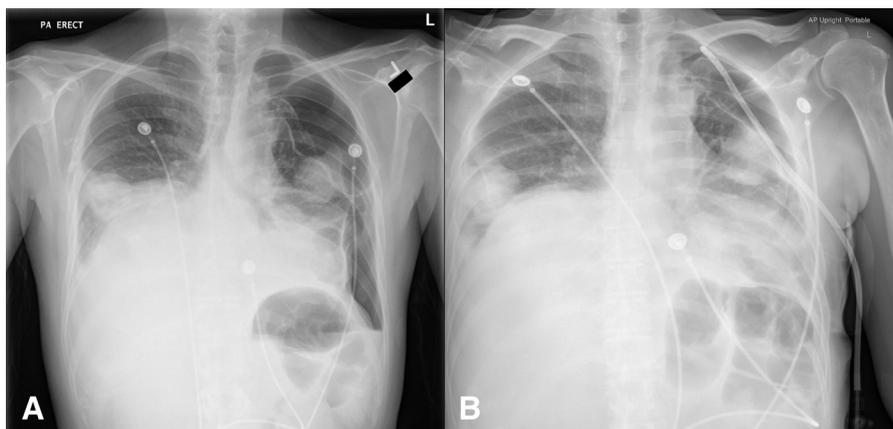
Clues to retained catheter obturator. (A) Initial chest radiograph. A left pneumothorax is present. (B) A 14.0-Fr pigtail catheter (Wayne Pneumothorax Tray; Cook Medical, Bloomington, IN) has been inserted. Several radiographic clues exist to indicate that the catheter is not correctly inserted. These are examined in subsequent figures. The catheter does not have the expected “pigtail” curved shape at its tip, but rather is straight. The obturator is visible within the intrathoracic portion of the catheter and extends out of the extracorporeal portion.
